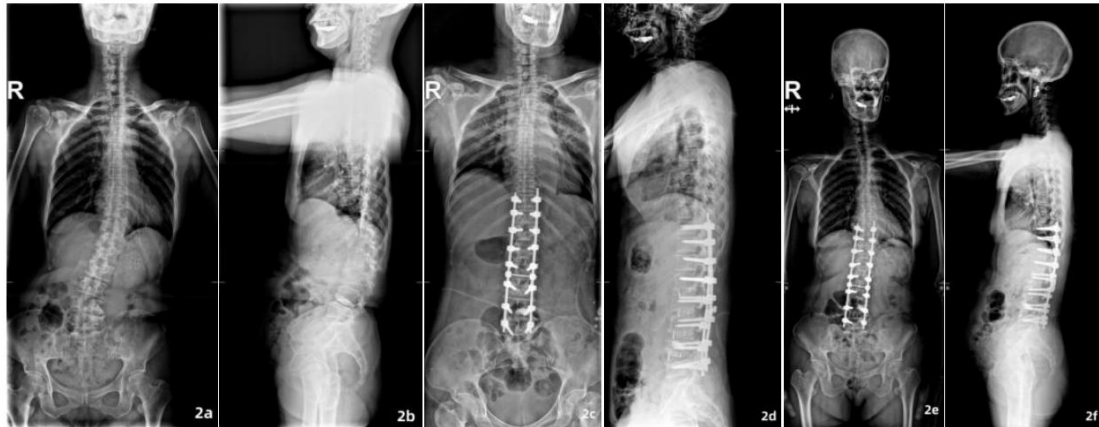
A 61-year-old male with Lenke-Silva grade IV adult degenerative scoliosis. Preoperative standing radiographs (a, b) Postoperative radiographs (c, d) revealed satisfactory correction. Final follow-up radiographs (e, f) showed sustained alignment, solid interbody fusion, and stable implants.
